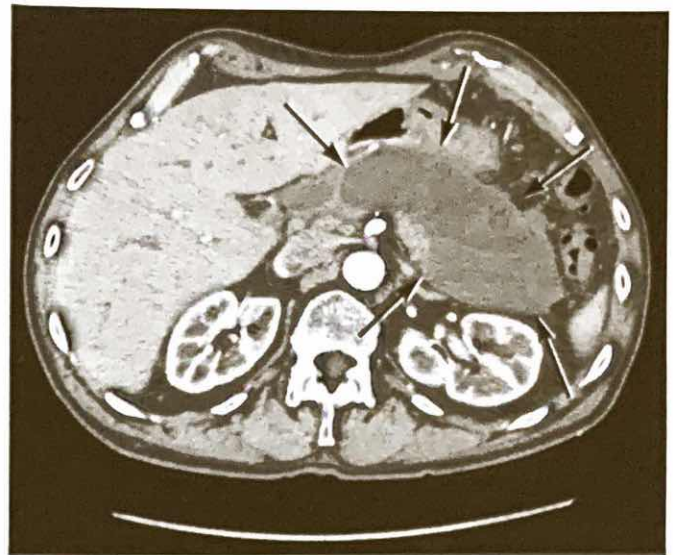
CT scan showing maturation and liquefaction of pancreas necrosis of nearly the entire pancreas over 4 weeks' duration with a well-defined rim or wall (arrows), known as walled-off necrosis.
